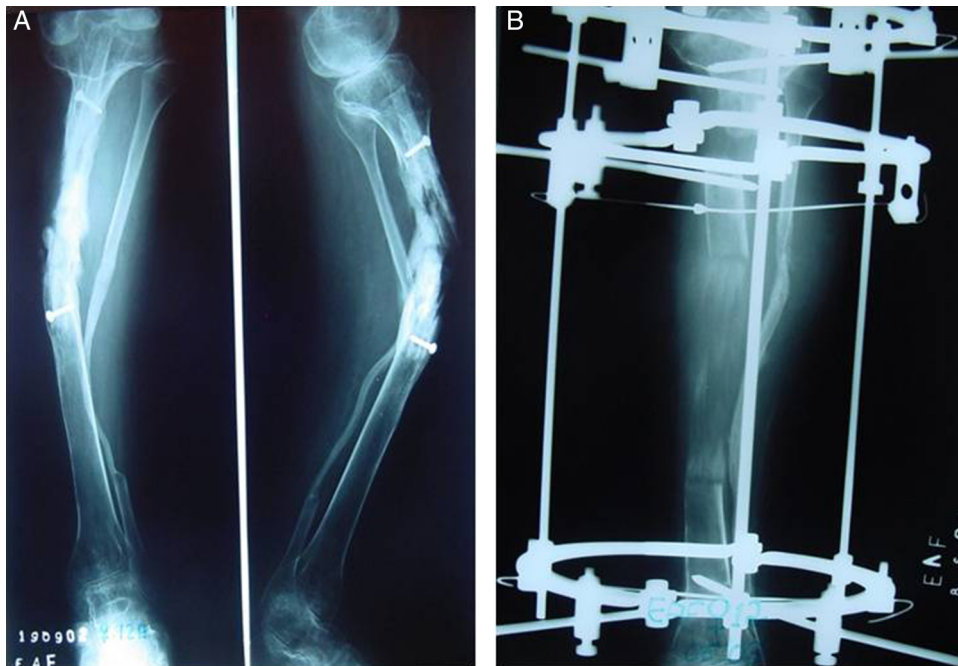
Radiographs in anteroposterior and profile of a chronic osteomyelitis that had been operated several times (A) and after diaphysectomy and bone transport to fill the gap (B).
